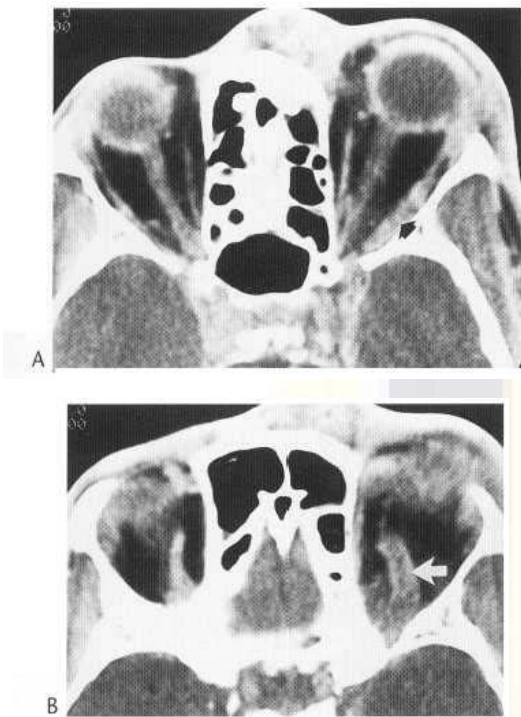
Cavernous sinus thrombosis. Axial CT image (A) demonstrates proptosis with preseptal soft-tissue swelling and enlargement of the left lateral rectus muscle (arrowhead). There is subtle enlargement of the left cavernous sinus, with areas of diminished enhancement. Image at a higher level (B) demonstrates massive distension of the left superior ophthalmic vein (arrow).
